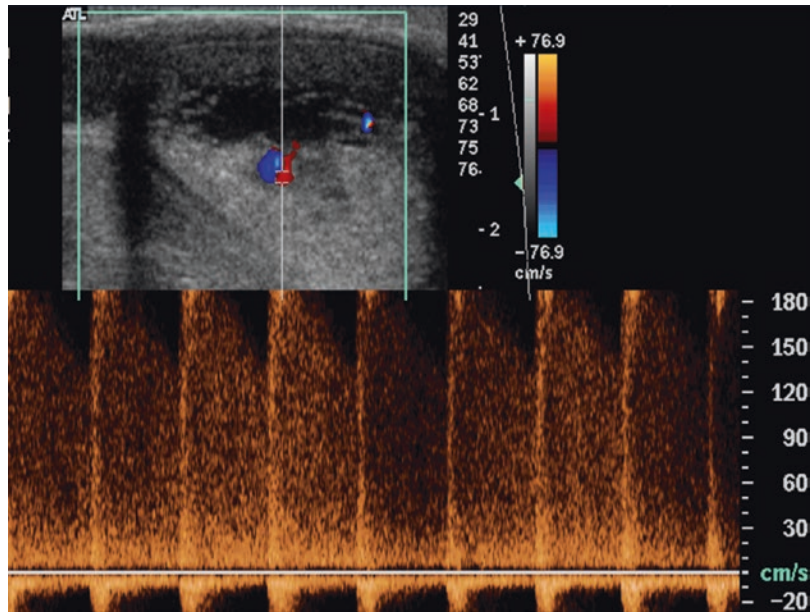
Posttraumatic high-flow priapism. Duplex Doppler interrogation of the cavernosal artery tear showing high-velocity, turbulent flows
